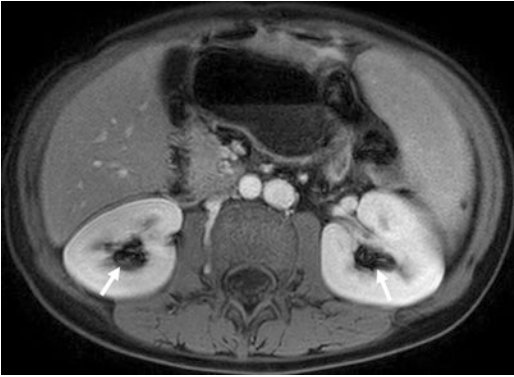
Axial postcontrast T1-weighted fat-suppressed MR image shows dark signal (signal voids) in the renal collecting systems (arrows) due to concentrated gadolinium-based contrast material and its impact on T2 relaxation
